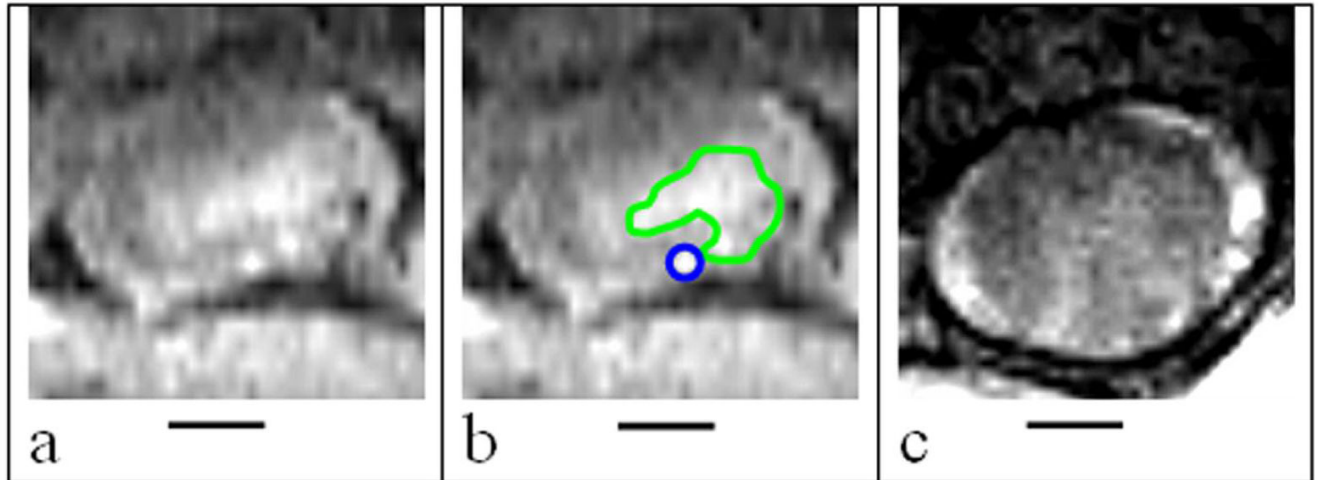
Representative axial DCE-MR images containing the different areas of interest (FE area is outlined in blue and DE area is outlined in green). The NE area is calculated by subtracting the FE and DE areas from the entire spinal cord ROI. (a) An axial T1-weighted MRI slice of the spinal cord; (b) the same slice as in (a), with DE and FE areas outlined in green and blue respectively; and (c) an example of a slice that contains only NE areas. The hyperintense ring around the spinal cord contains cerebrospinal fluid (4). Bars represent 1 mm.
